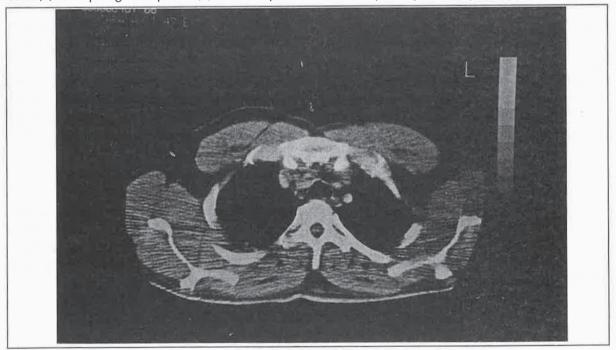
CT scan showing a peripherally located tumor, highly suggestive of pleural origin with fatty tissue density (-123 H.U.)
